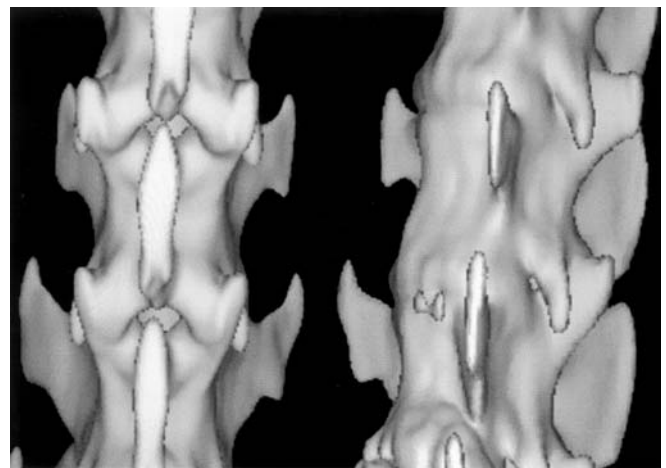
On these three-dimensional computed tomography (CT) reconstructions (anterolateral oblique view on right, posterior on left side of the figure), a small double bony spur at the left anterolateral entrance is visualized between the transverse processes, which protrude slightly anterior (right side). Facet joints remain unaltered (left side of the picture). The anterolateral osteophyte had not been visible on standard radiographs
